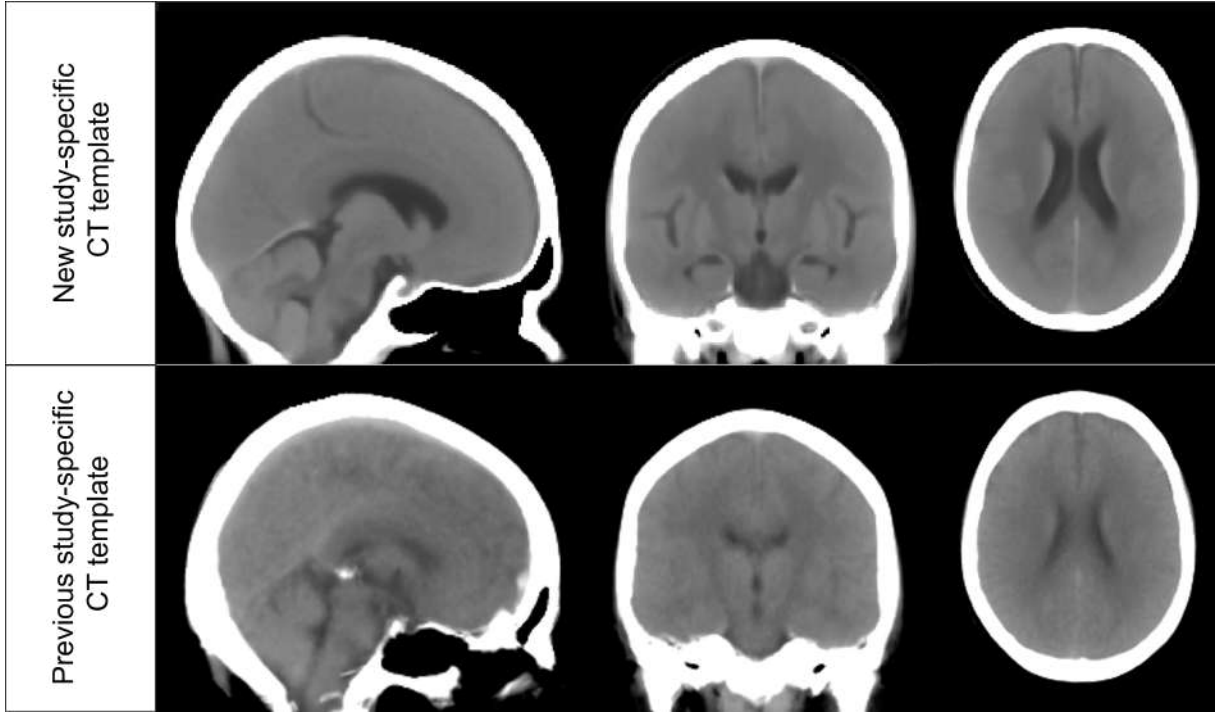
Final study-specific CT template, resulting from the 7th registration iteration, and previously created CT template, constructed in the context of the development of the initial version of BLAST-CT.
